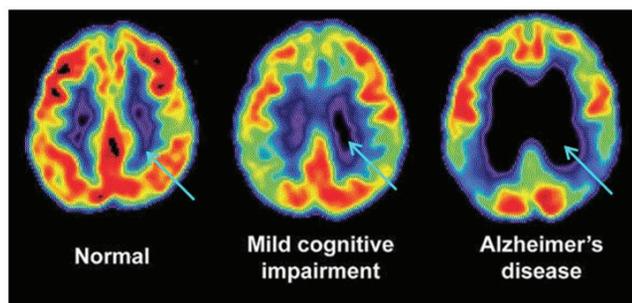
[^{18}F]FDG PET showing metabolic differences in normal and pathological human brains. Orange areas show high glucose uptake and increased metabolism, while spreading dark spots indicate progressive neurodegeneration and cell death.
